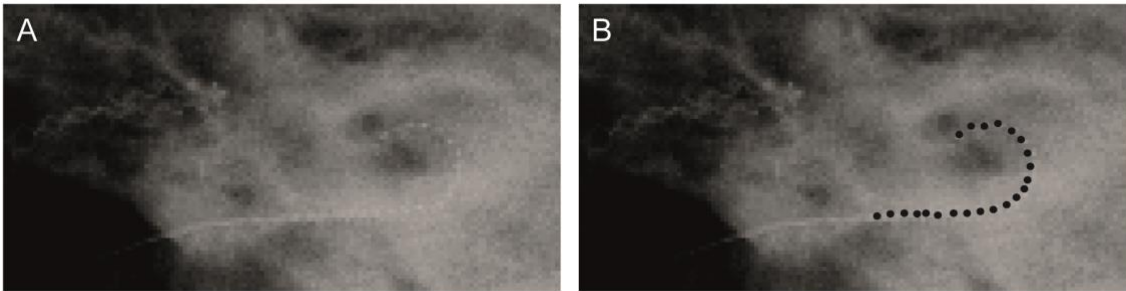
Full insertion demonstrated by X-ray images captured following implantation surgery
